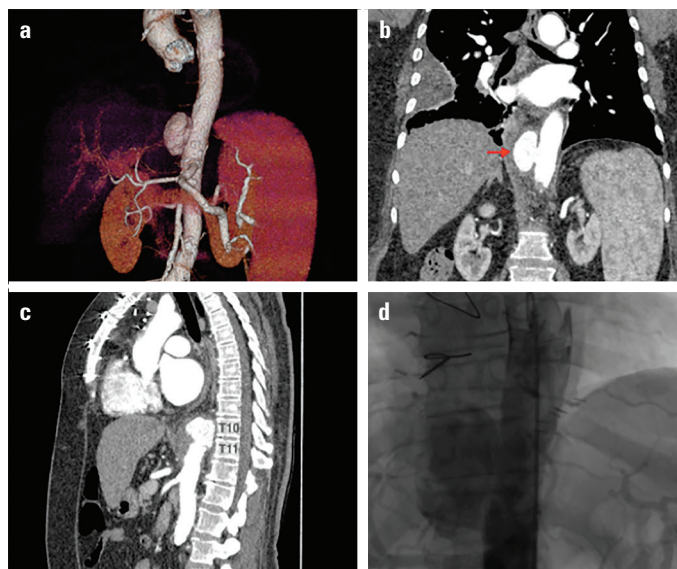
(a) 3-D view of the saccular aneurysm on multidetector computed tomography (MDCT) of the thorax and abdomen. (b) MDCT of the thorax and abdomen revealed a large saccular aneurysm in the descending aorta (red arrow). (c) MDCT of the thorax and abdomen reveals the saccular aneurysm in the descending aorta at the 10th-11th vertebral levels. (d) Aortic angiography showed the saccular aneurysm in the descending aorta during the procedure
